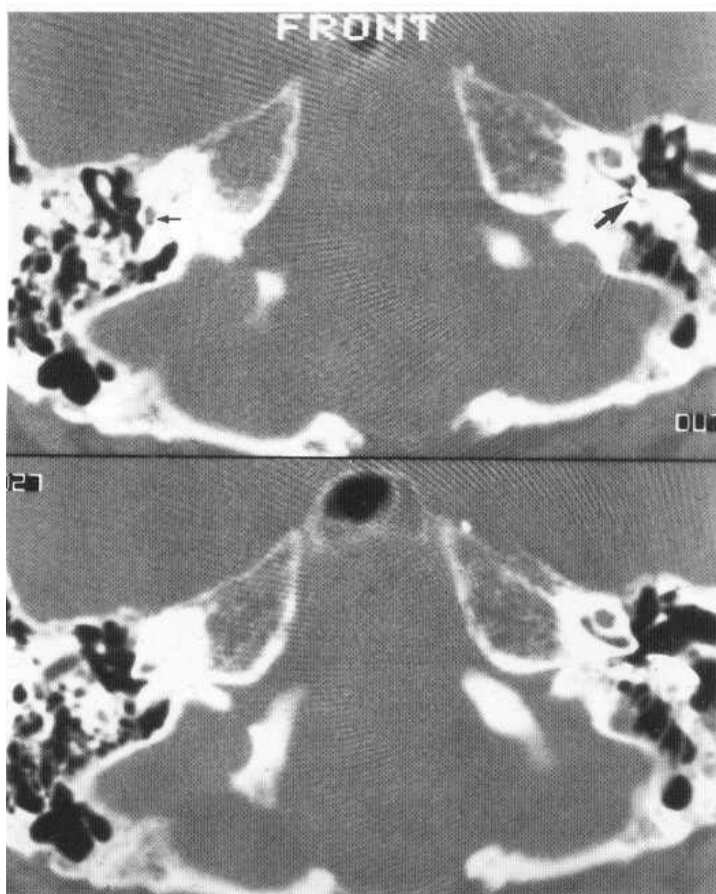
Axial CT scan through the basal turn of the cochlea. On one side a single channel cochlear implant has been inserted in the round window (large arrow); on the other side there is labyrinthitis obliterans with only the hook of the basal turn readily apparent (small arrow).
